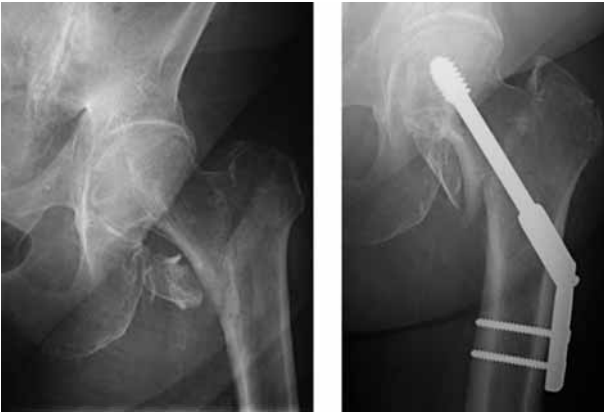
AP radiograph of the left hip showing the fracture of the proximal femur before and after internal fixation with a DHS.
